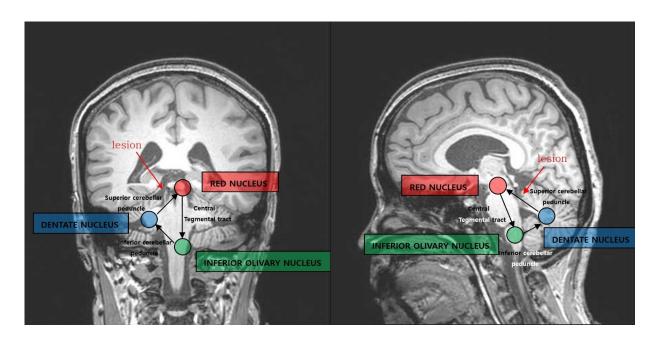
Coronal and Sagittal T2-weighted MRI showing lesions in the triangle of Guillain and Mollaret
